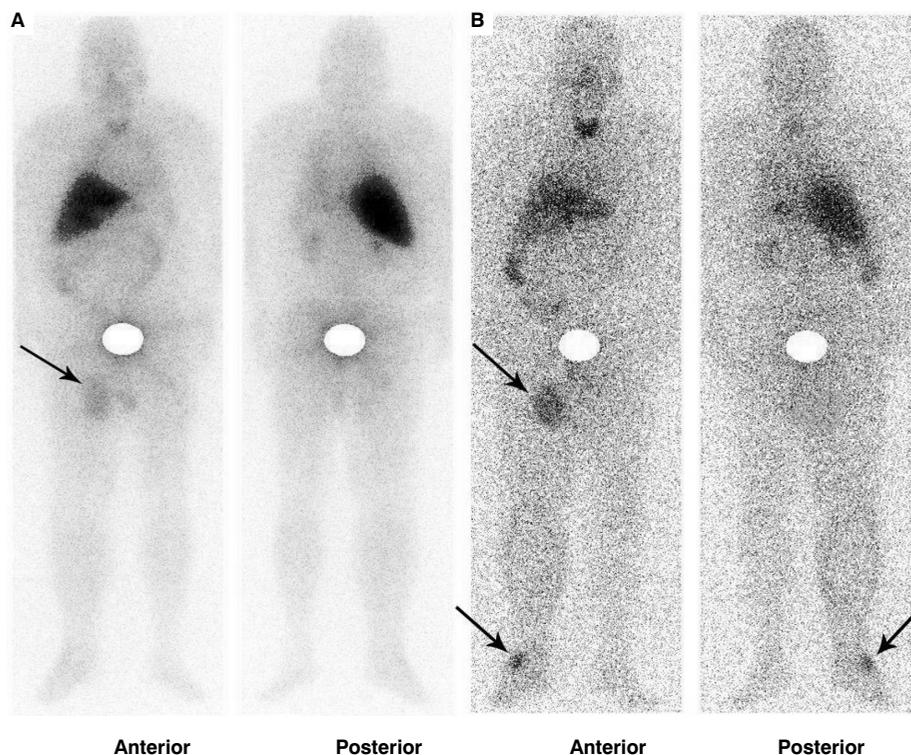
Whole body scintigram of a patient with melanoma metastases to soft tissue of the right leg (black arrows). A. 4 hours after radiopharmaceutical injection; B. 24 hours after radiopharmaceutical injection; radioactivity in urinary bladder on images has been masked; focus of increased radiopharmaceutical uptake in right foot visible only on image recorded 24 hours after tracer injection.
